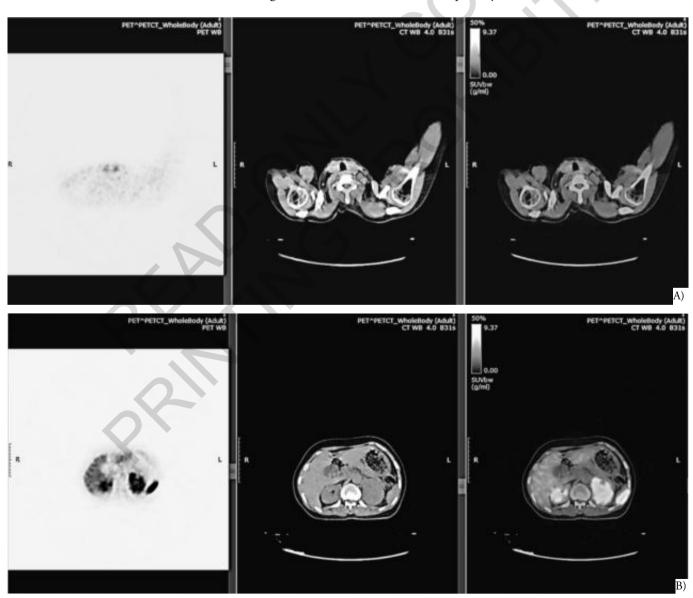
A) Increased SUVmax (3,3) at left lobe of the thyroid; B Left adrenal mass with a high SUVmax (9,1).
